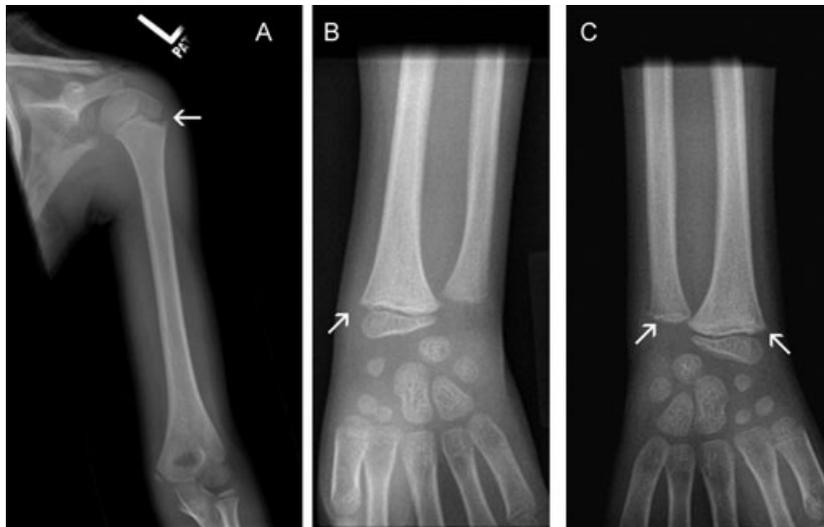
Postmortem radiographs demonstrating epiphyseal irregularities and radiolucencies centered about the proximal left humeral epiphysis (A, arrow) and the distal left and right radial epiphyses (B and C, arrows) and distal right ulnar epiphysis (C, arrow).
